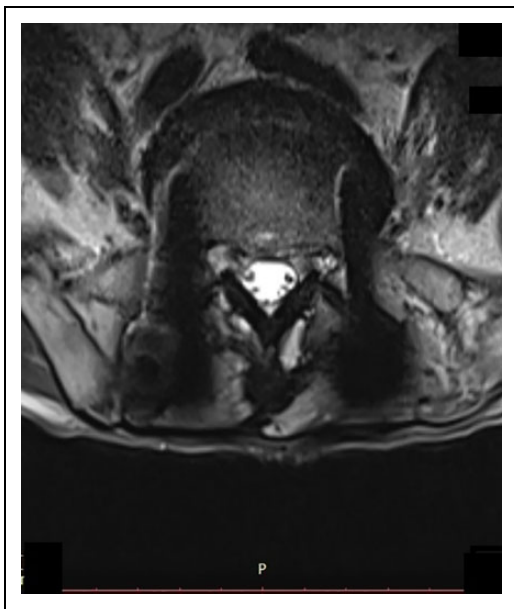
Axial magnetic resonance image of same patient at L5-S1 level.
